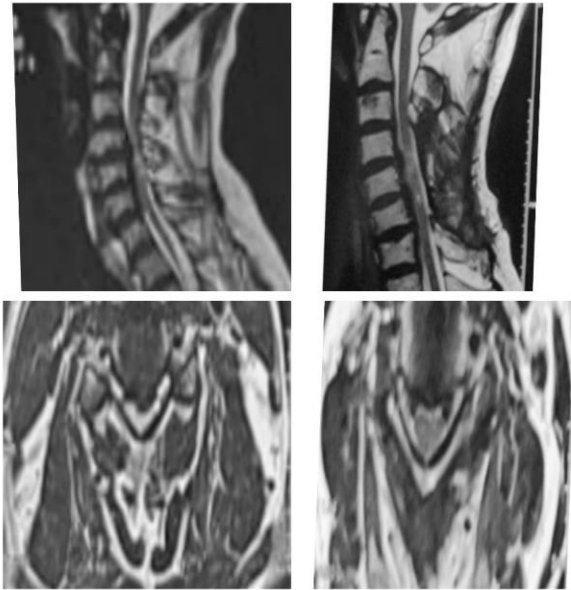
a,c; Pre- operative MRI sagittal and axial images of cervical spine showing significant compression; b,d: Showing post operative MRI sagittal and axial scan images of patient with laminectomy.
